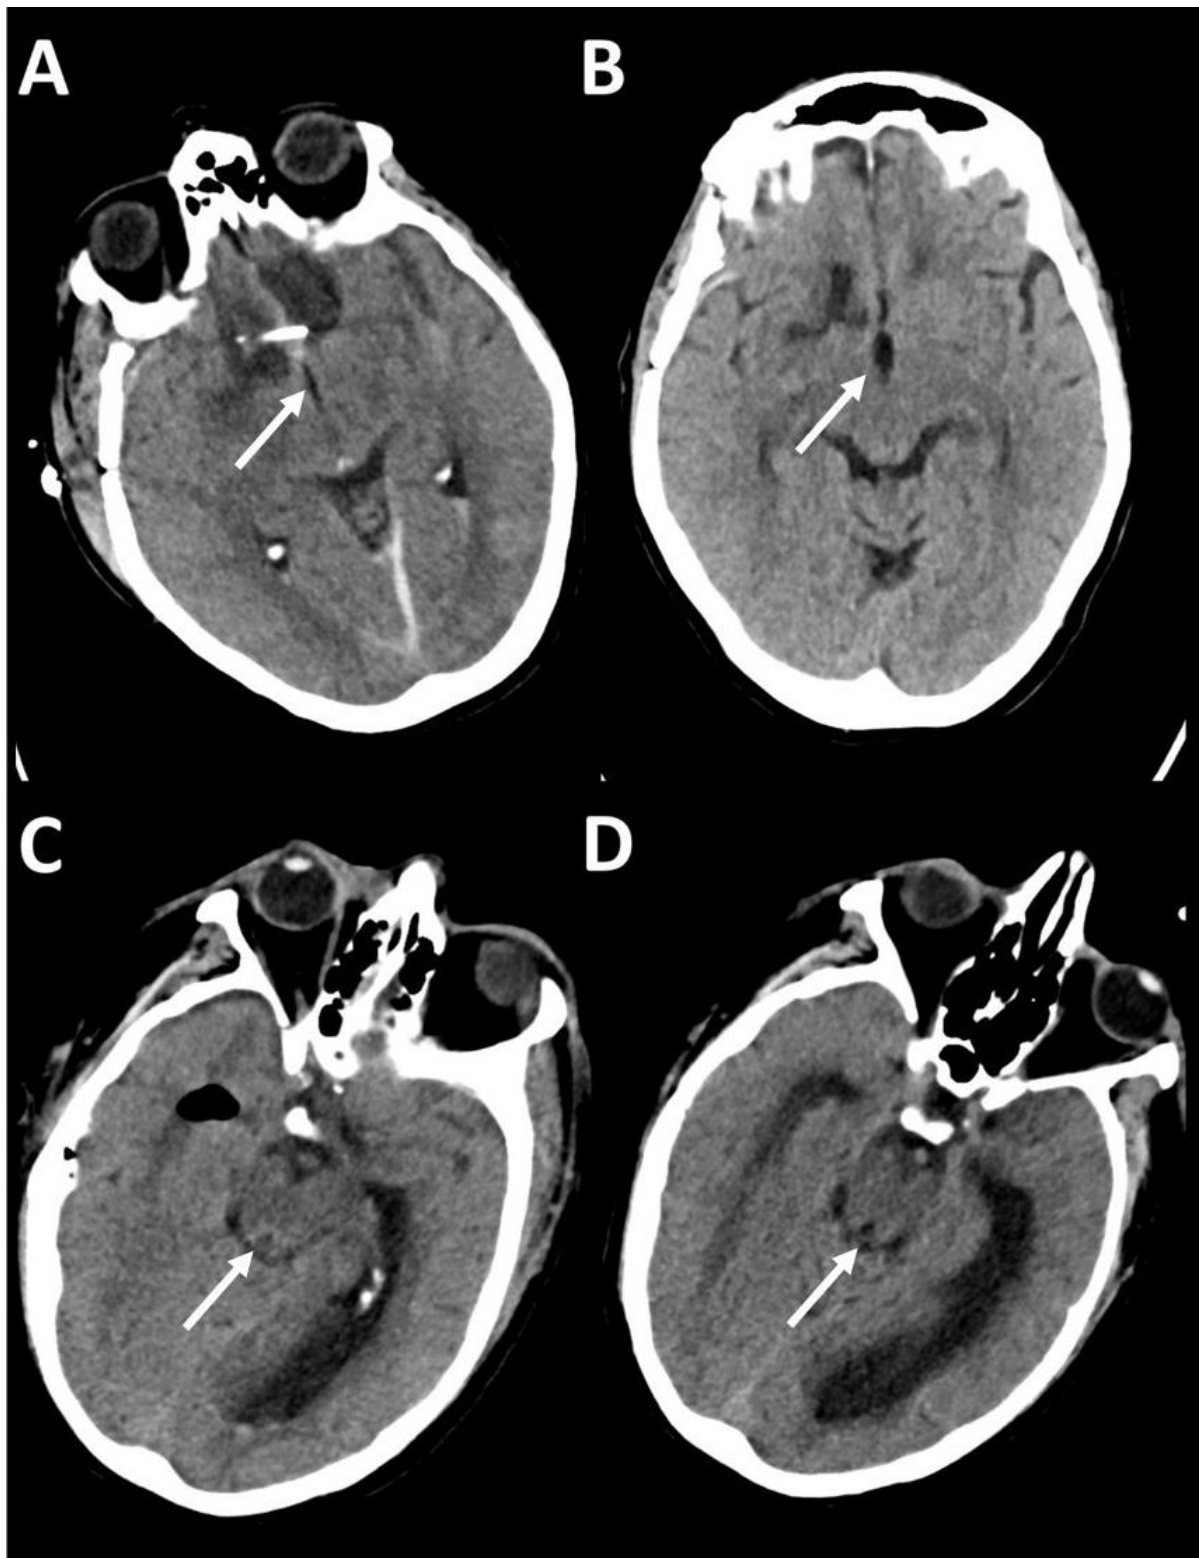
Computed Tomography (CT) Head. CT head showing the third ventricle prior to (A) and 24 hours after (B) external ventricular (EVD) clamping. There is marked enlargement of the third ventricle. CT head at the level of the cerebral aqueduct prior to (C) and 24 hours after (D) EVD clamping. The cerebral aqueduct had significant increase in diameter.
